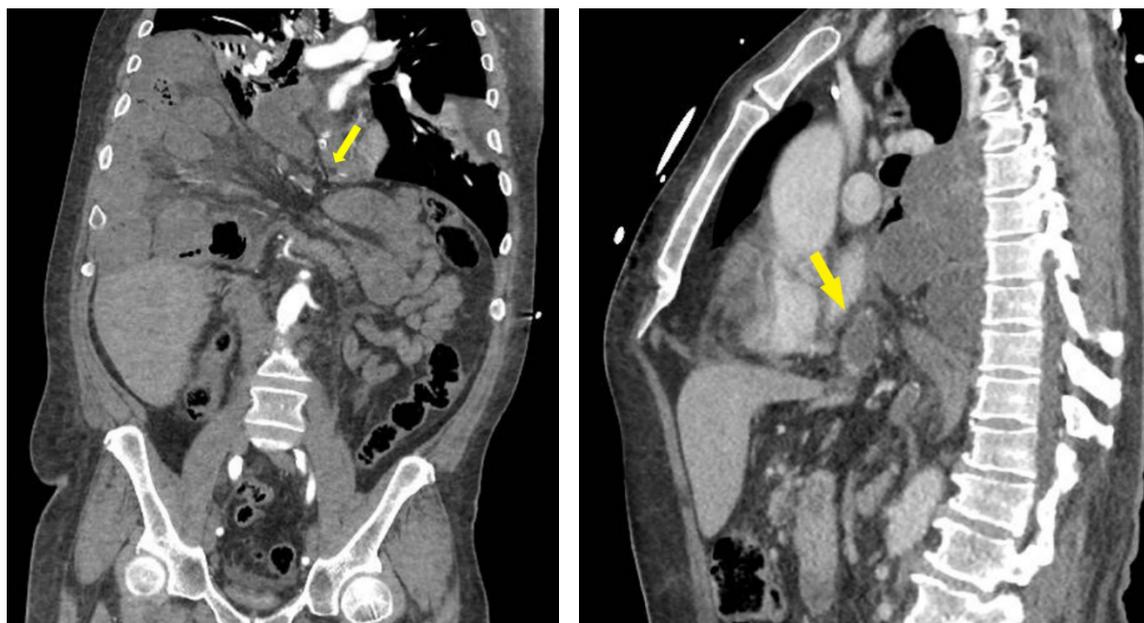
Chest and abdomen computed tomography (coronal and sagittal) showing large amount of small bowel herniated through the esophageal hiatus of the diaphragm (yellow arrow).
